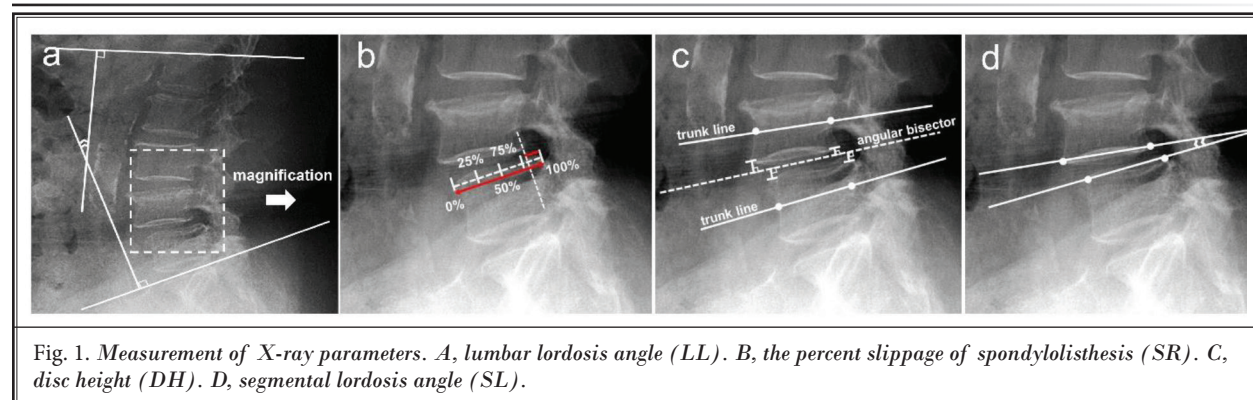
Measurement of X-ray parameters. A, lumbar lordosis angle (LL). B, the percent slippage of spondylolisthesis (SR). C, disc height (DH). D, segmental lordosis angle (SL).
